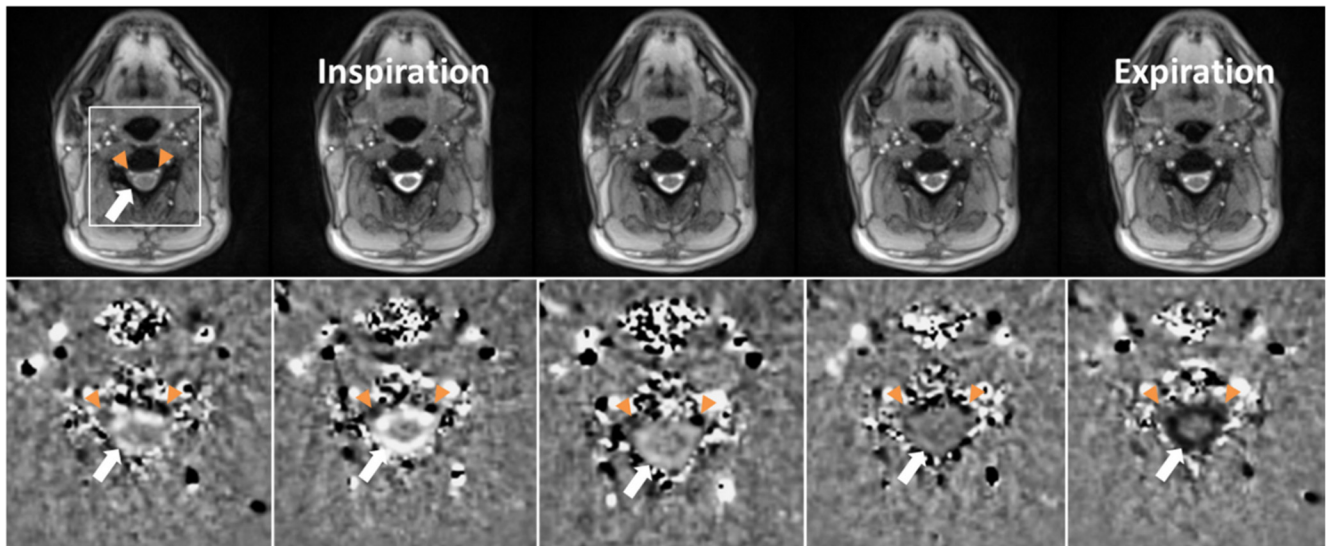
CSF flow and simultaneous venous blood flow at C3 during one respiratory cycle (inspiration and expiration). Serial magnitude images (top) and corresponding phase-contrast velocity maps from left to right (bottom) were selected from a real-time MRI video at 135 ms temporal resolution (every seventh frame, period of 3.78 s, subject #1). Bright CSF flow velocities in the ring-like subdural spinal space (white arrow) indicate upward movement with onset of forced inspiration. Concurrently, the epidural veins (left more than right) (orange arrowheads) exhibit a remarkably dark (i.e., downward) flow signal. During expiration, the CSF flow direction is reversed (dark signal) and the velocity of the epidural veins diminishes (dark signal less pronounced).
